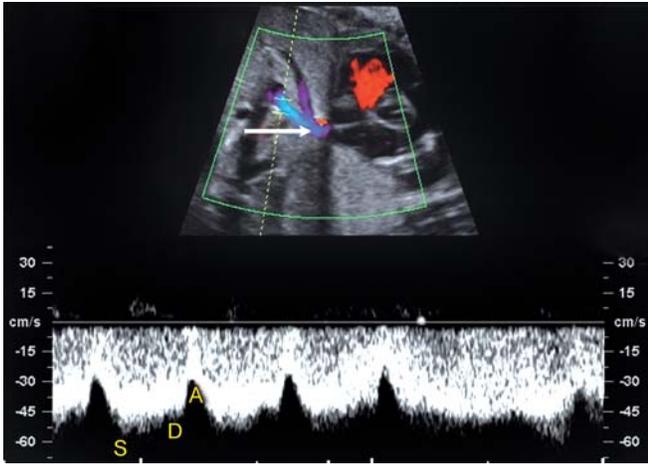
Ductus venosus spectral Doppler signature
